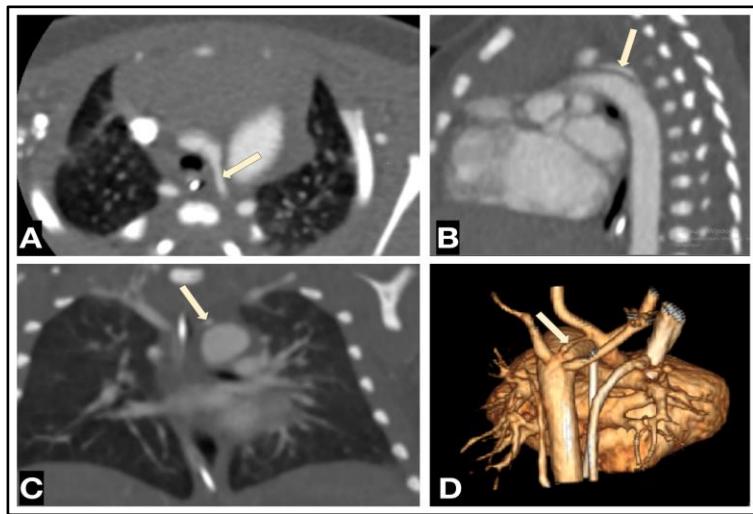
CTA multiplanar images of a 5-day-old patient with AAH. (A) Axial plane, (B) sagittal plane, and (C) coronal plane demonstrate the narrowed transverse aortic arch, indicated by the yellow arrow. (D) Three-dimensional volume-rendered reconstruction provides an overview of the aortic arch anatomy, with the hypoplastic segment similarly highlighted
